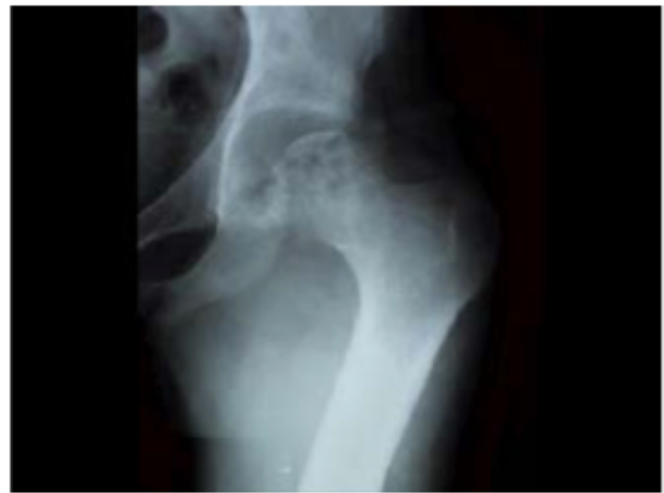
Hip X-ray at the moment of diagnosis, showing lesser bone mineralization, opening of the joint surfaces and bone turnover areas on proximal femoral epiphysis.
